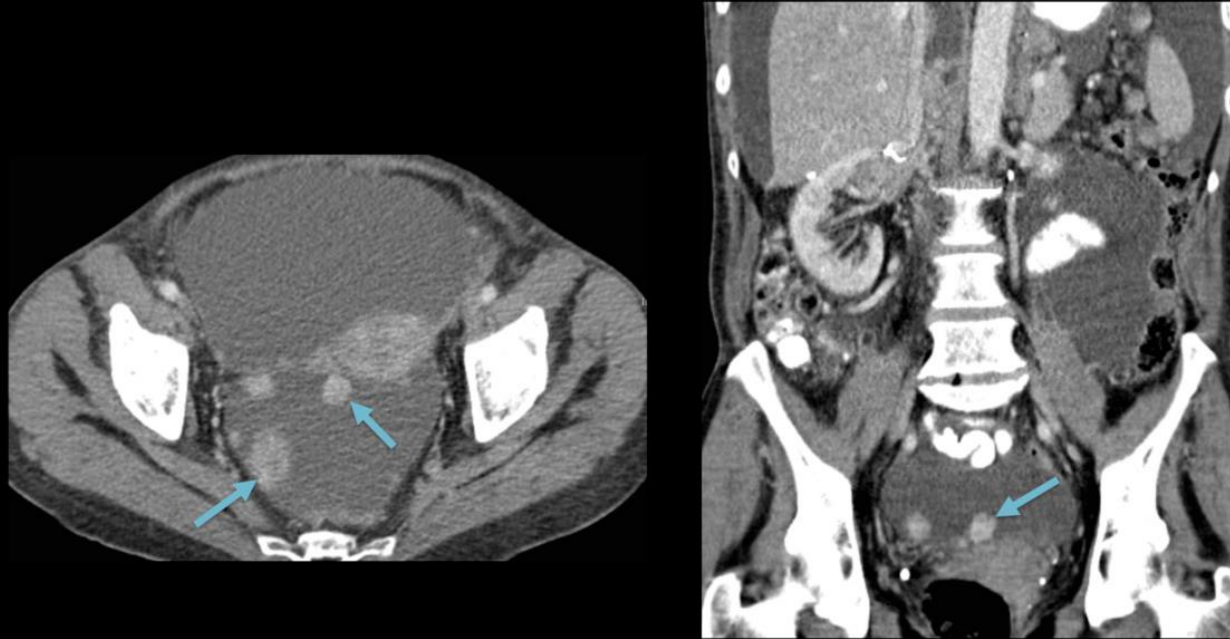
Nodular implants in Douglas pouch. Axial and coronal CT images in a female patient with advanced adrenocortical carcinoma showing ascites and multiple enhancing nodular masses in the rectouterine recess, representing peritoneal implants.
